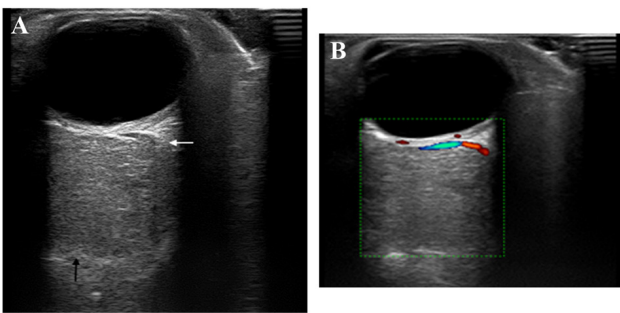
The representative Color Doppler flow imaging results showed a small amount or no signs of internal blood flow. (A) The optic nerve (white arrow) is displaced by the lesion (black arrow) in a 44-year-old male patient. (B) No obvious blood flow signal was observed within the lesion in a 44-year-old male patient.
